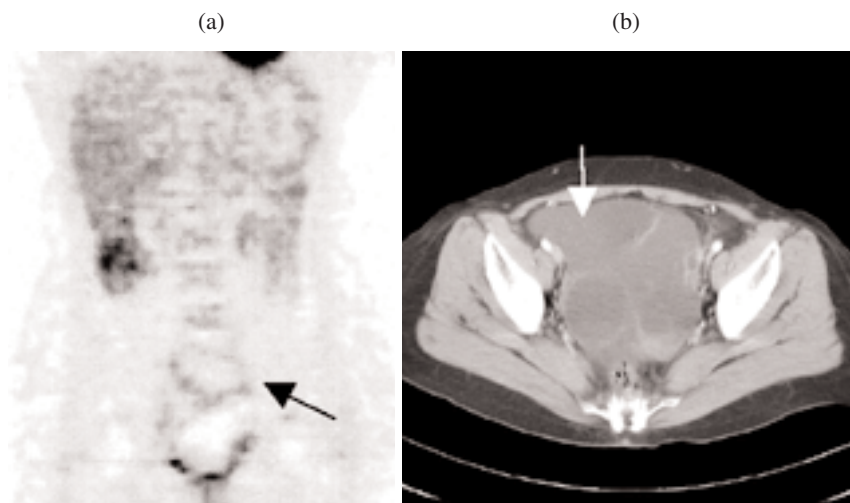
Patient 4 (a case of low grade ESS): (a) whole body FDG-PET detected recurrence of pelvic cystic lesions which had increased intensity of ¹⁸F₂ uptake in peripheral area (black arrow, coronal view) (b) abdominal CT revealed clearly recurrent cystic tumors (white arrow, transaxial view).
